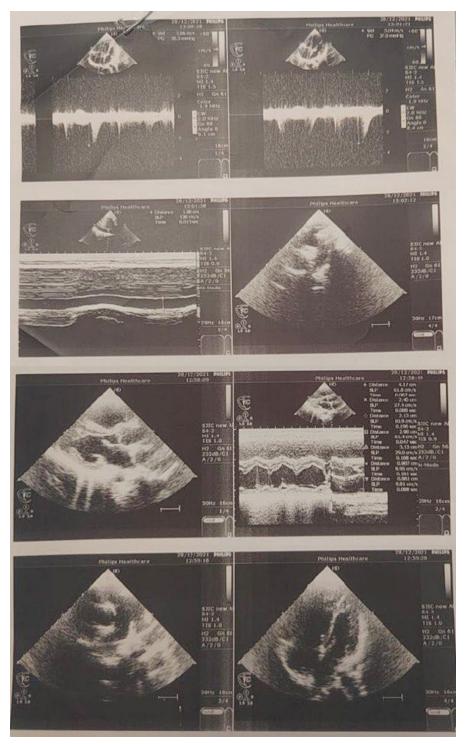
2D-echocardiogram shows dilated Right Atrium (RA) and right ventricle (RV), mildly dilated pulmonary artery (PA), Mild regional wall motion abnormality (RWMA), Mild mitral regurgitation (MR), Mild tricuspid regurgitation (TR), Mild aortic regurgitation (AR), mildly dilated inferior vena cava (IVC), RV dysfunction, PAPVC+, left ventricular ejection fraction (LVEFf): 60%
